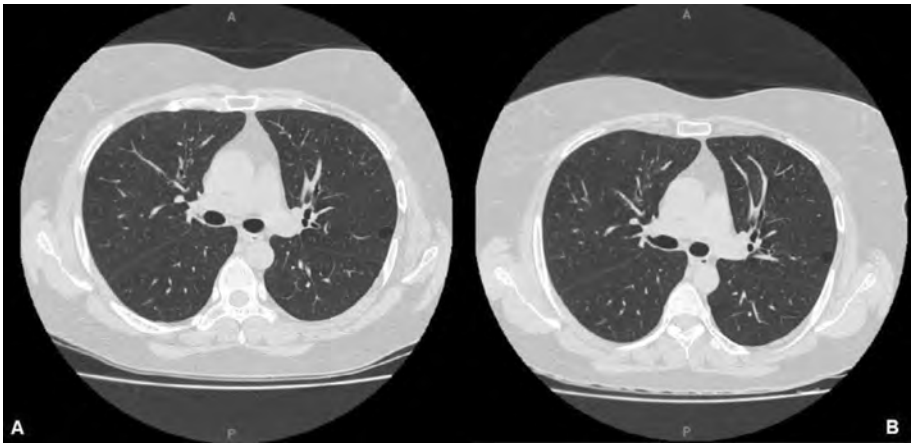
Thoracic imaging of a 52-year-old woman with cystic lung disease. (A) CT scan done in 2018 with a lung cyst in left lung lobe. (B) New CT scan done in 2019 with no progression of the cyst.
